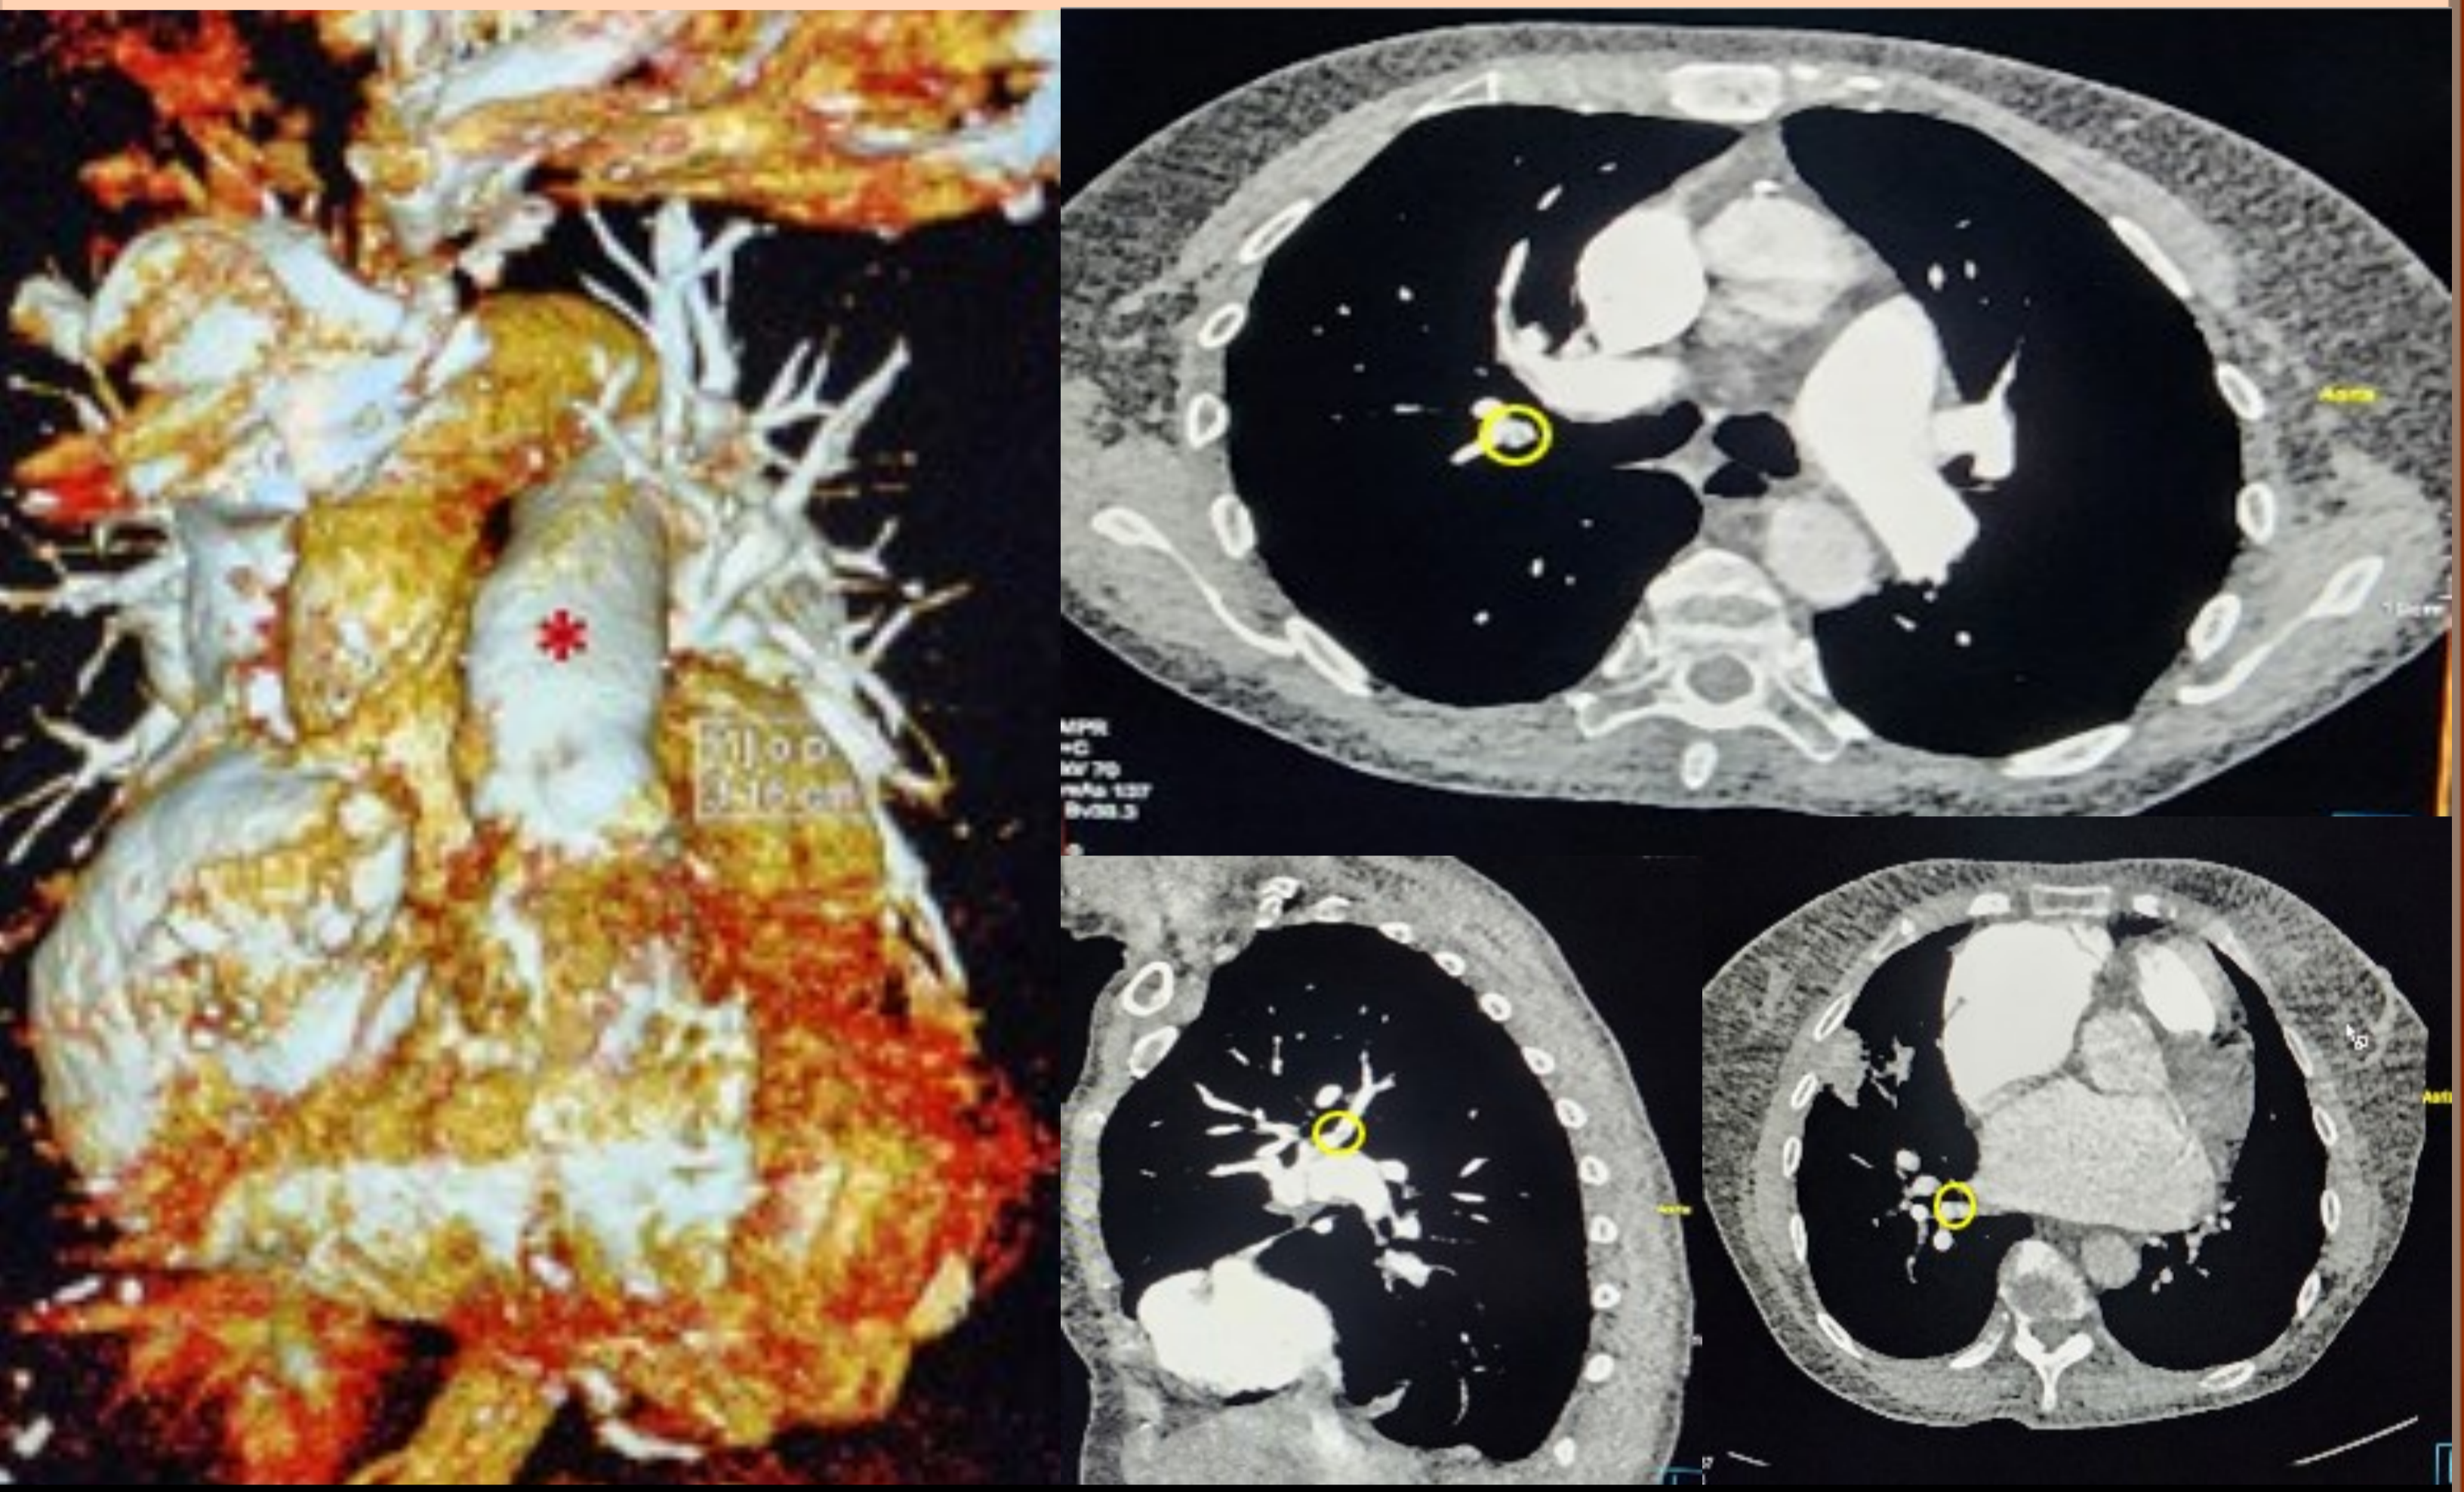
3D CT pulmonary angiogram (right) showing the dilated pulmonary trunk (red asterisk), and filling defects (yellow circle) in the right pulmonary artery (left).
